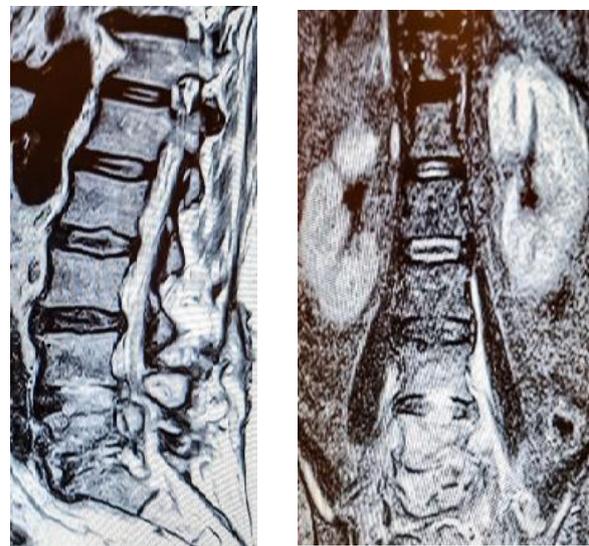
Immunocompromised patient with uncontrolled diabetes type 2. After 2 months post-fenestration at L4/L5 level presented with severe low back pain, elevated inflammatory markers. Sagittal (A) and coronal MRI T2-weighted (B) revealed massive height reduction of L5 vertebral body, edema and T2 hyperintensities at L4/L5 and L5/S1 along disc spaces and adjacent endplates suggestive for POD. Note the epidural abscess at the same level (A).
